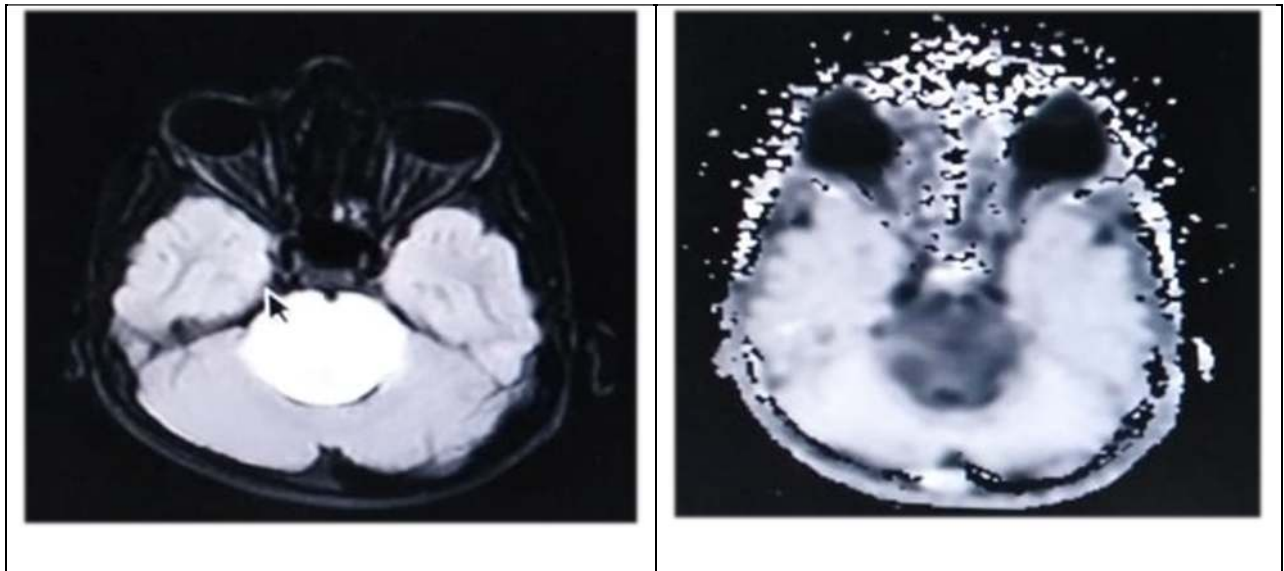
MRI Contrast enhanced images shows features of brain stem glioma. There is appreciated T1W, iso- intense T2W and FLAIR hyper intense well defined rounded lesion involving brain stem measuring 4×4cm with upwards extension to right half of mid brain and downwards extension up to medulla causing compression on 4th ventricle mild hydrocephalus. Lesion is showing subtle heterogeneous enhancement on post contrast scan.
